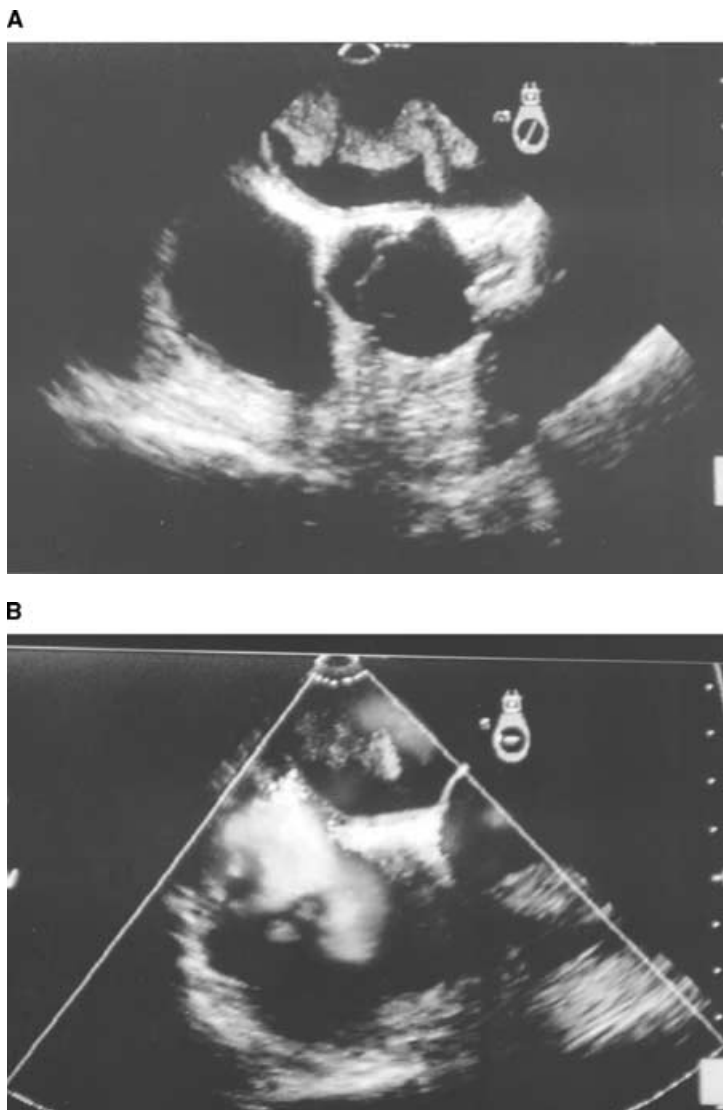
Transesophageal echocardiography showing a pediculated mobile nonhomogenous mass attached to the posterior wall of the left atrium (A) and a left to right shunt through ostium secundum atrial septal defect (B).*
